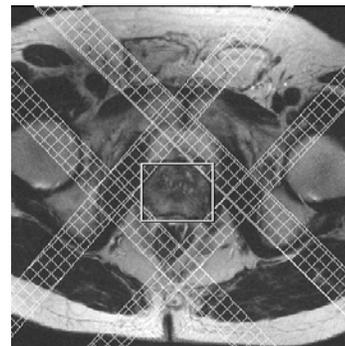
An axial T2-weighted image of a patient with prostate cancer with the PRESS box and outer volume saturation slabs of the MRSI pulse sequence around the prostate.
